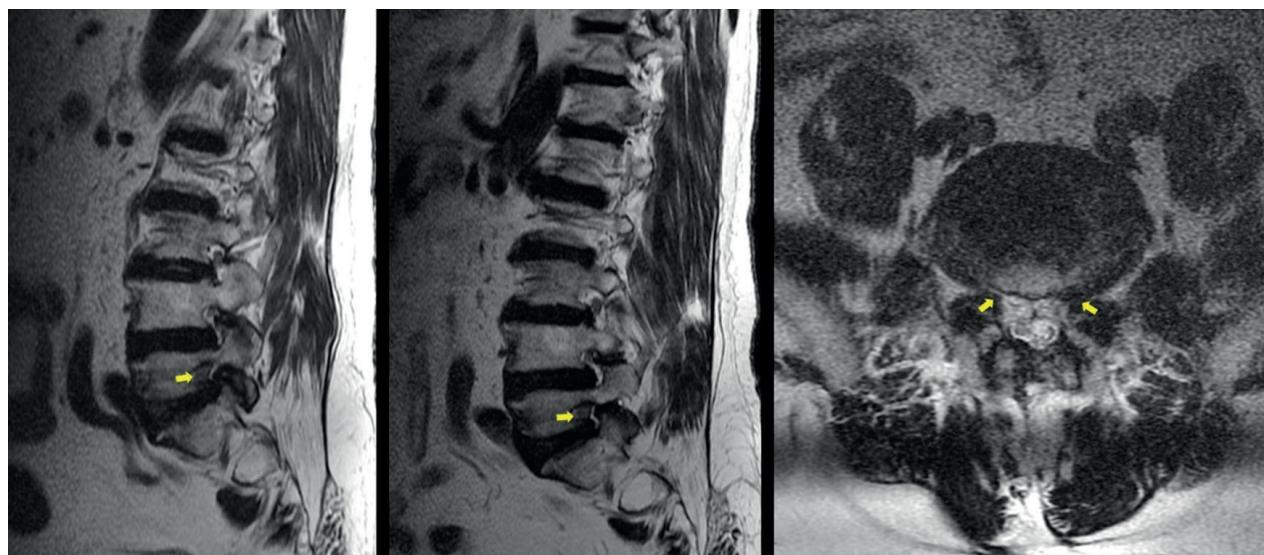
Sagittal and axial T2W lumbar MRI images show compression of bilateral S1 roots (arrows).
